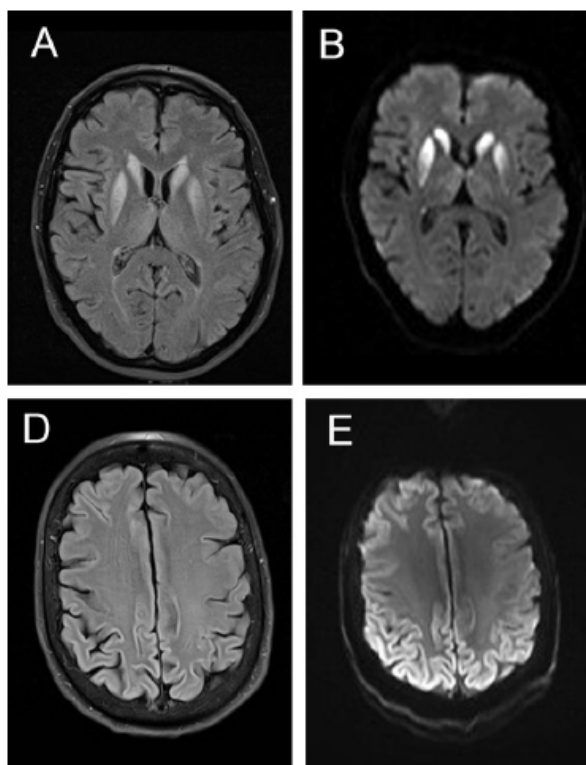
Different sequences of patients with definite sporadic Creutzfeldt-Jakob disease showing a typical increased signal in basal ganglia on Fluid-attenuated inversion recovery (FLAIR) (A), Diffusion-weighted images (DWI) (B) and typical features of cortical ribboning in cerebral cortex on FLAIR (D), DWI (E) sequences. (42).
